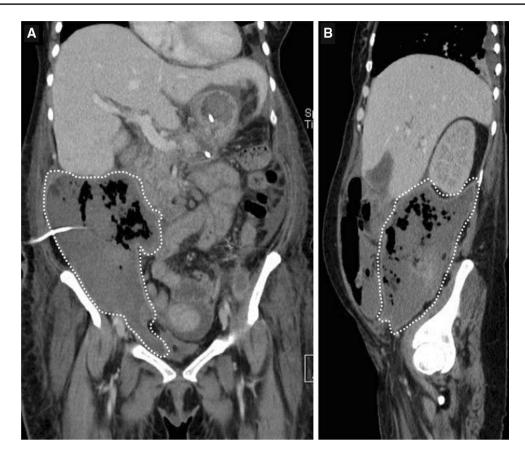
Case #1. a Coronal CT image of right-sided walled-off necrosis (dotted line) with percutaneous plastic drain. b Sagittal image of WON
